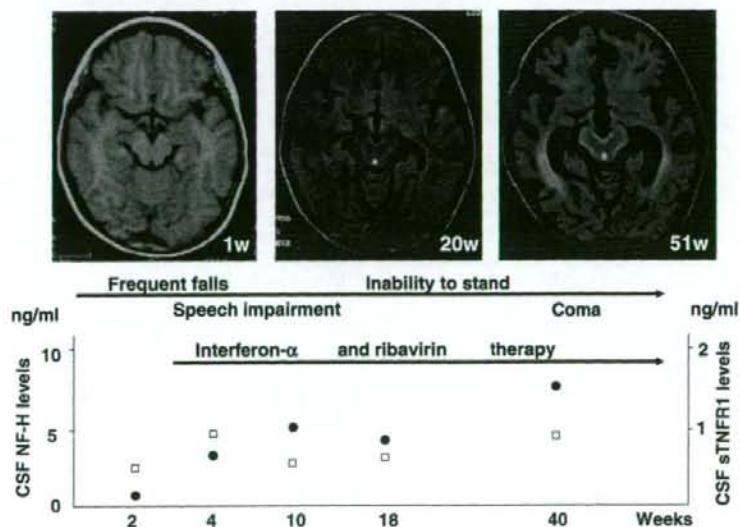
Clinical course, serial brain MRI, CSF NF-H and sTNFR1 levels in a 10-year-old Japanese boy with SSPE. Circles and squares indicate CSF NF-H and sTNFR1 levels, respectively.
